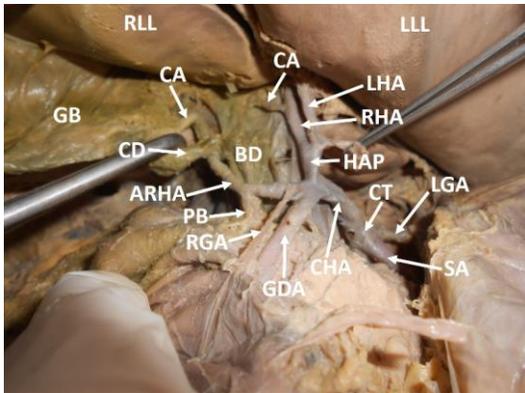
Dissection of the variant branching pattern of celiac trunk showing the additional right hepatic artery (ARHA) and its branches. (CT – celiac trunk; LGA – left gastric artery; SA – splenic artery; CHA – common hepatic artery; HAP – hepatic artery proper; RHA – right hepatic artery; LHA – left hepatic artery; CA – cystic artery; GDA – gastroduodenal artery; PA – large pancreatic artery from the additional right hepatic artery; RGA – right gastric artery; CD – cystic duct; BD – bile duct; GB – gall bladder; RLL – right lobe of liver; LLL – left lobe of liver)
